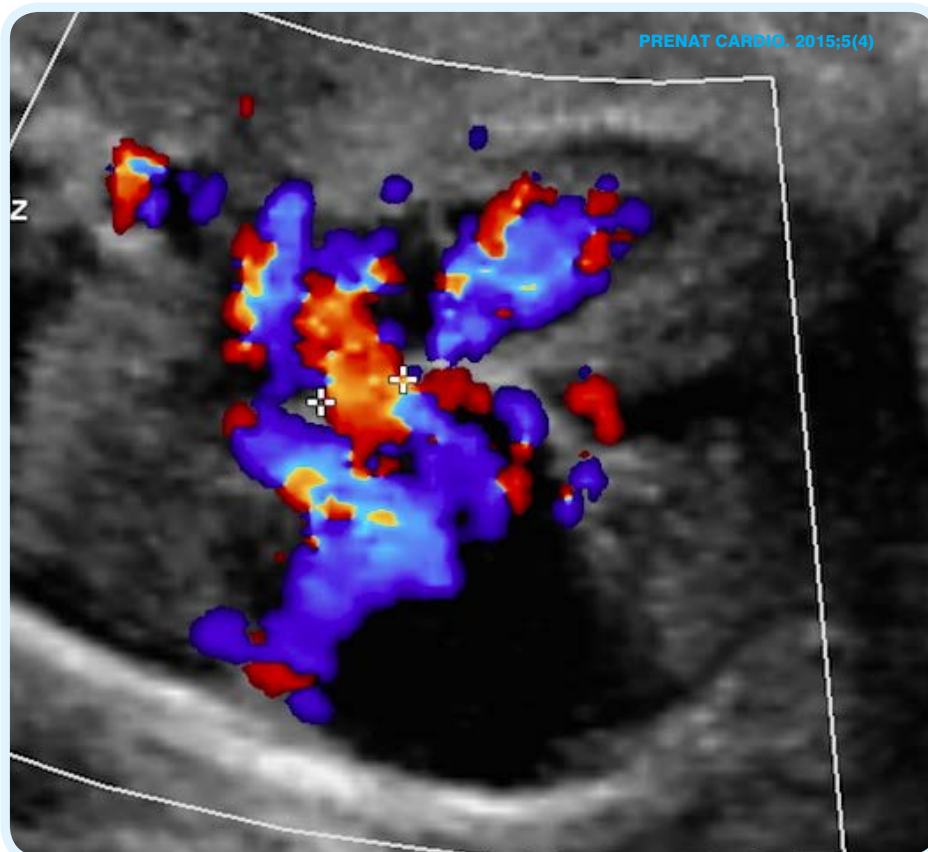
Prenatal echocardiogram. Foramen ovale + diminished flow across right/left atrium
